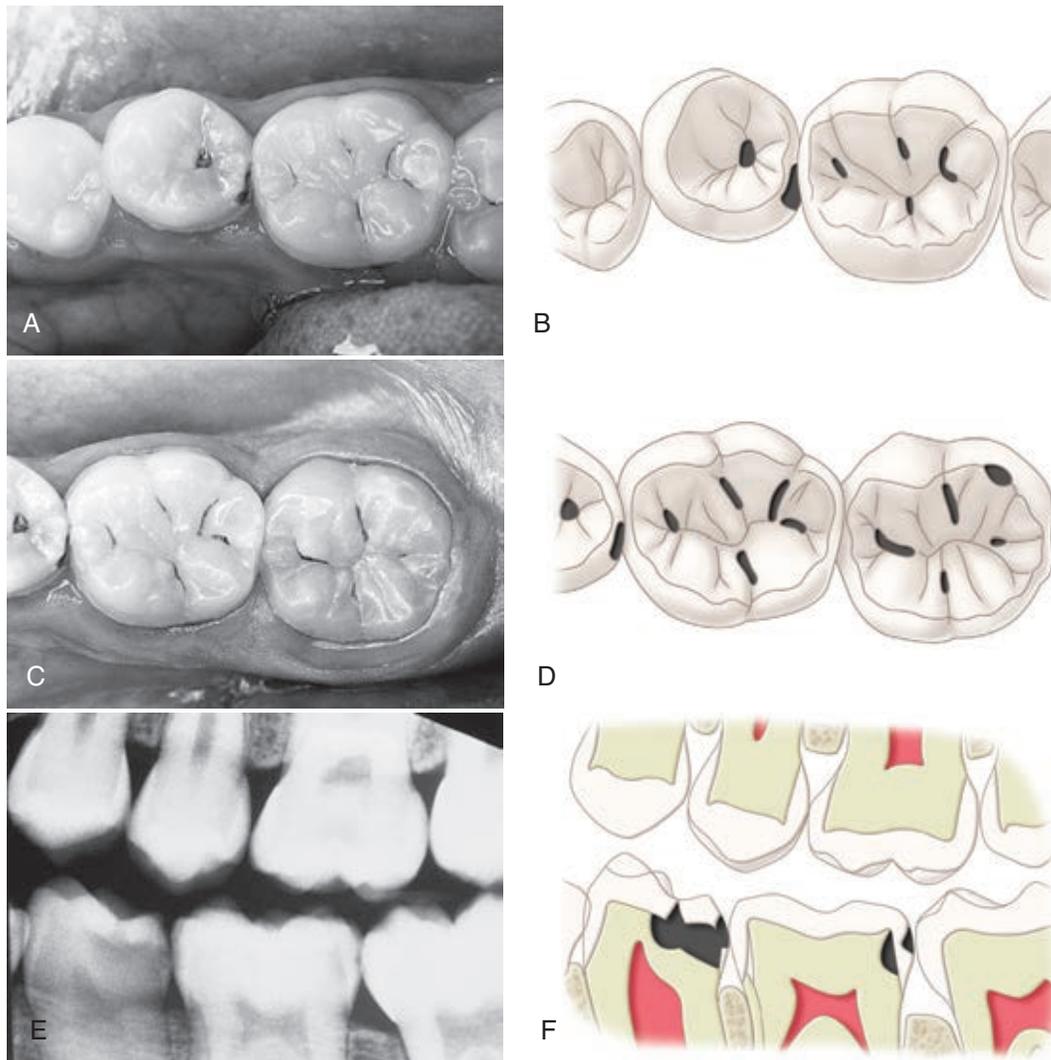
A young patient with extensive caries. A and B, The occlusal pits of the first molar and second premolar are carious. An interproximal caries lesion is seen on the second premolar. The second premolar is rotated almost 90 degrees, bringing the lingual surface into contact with the mesial surface of the first molar. Normally, the lingual surfaces of mandibular teeth are rarely attacked by caries, but here, the tooth rotation makes the lingual surface a proximal contact and, consequently, produces an interproximal habitat, which increases the susceptibility of the surface to caries. C and D, The first and second molars have extensive caries in the pits and fissures. E and F, On the bitewing radiograph, not only can the extensive nature of the caries in the second premolar be seen but also seen is a lesion on the distal aspect of the first molar, which is not visible clinically. (Dark areas in B, D, and F indicate caries.)
